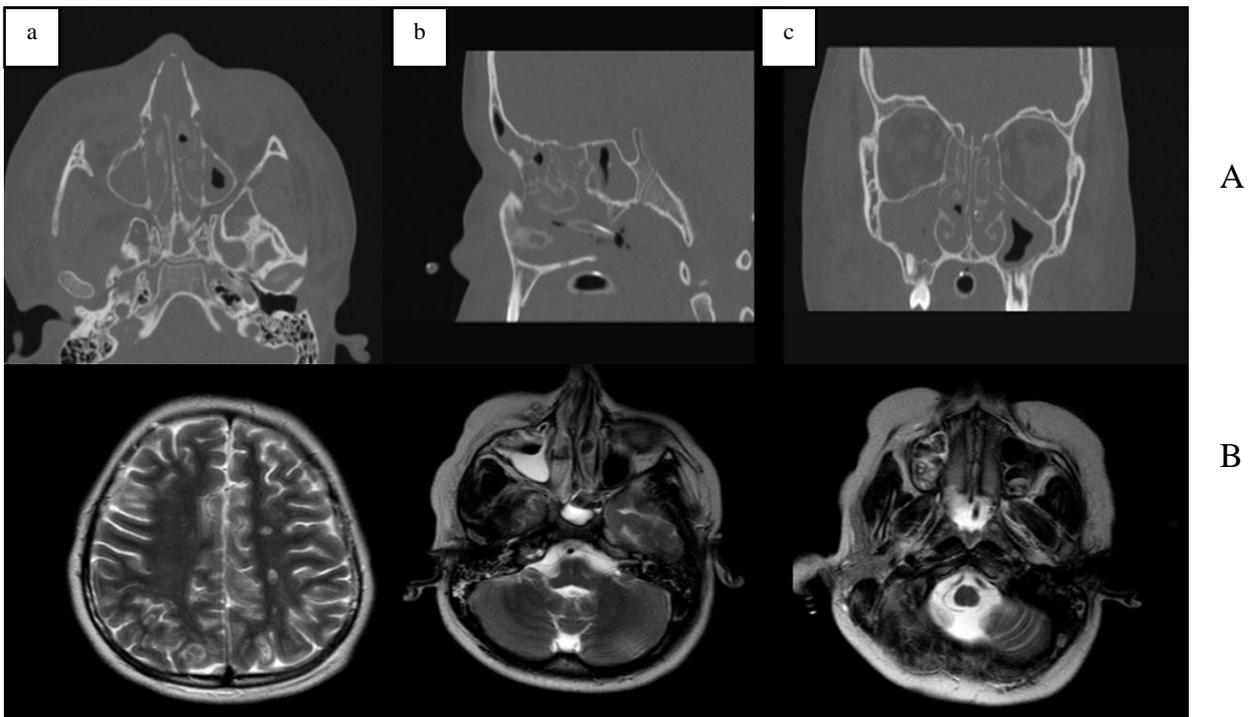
a) Axial spiral computed tomography of paranasal sinuses with reconstructed. b) sagittal and c) coronal images indicate opacified paranasal sinuses supplemented by bony remodeling related to long-lasting chronic sinusitis with opacified nasal cavity.
